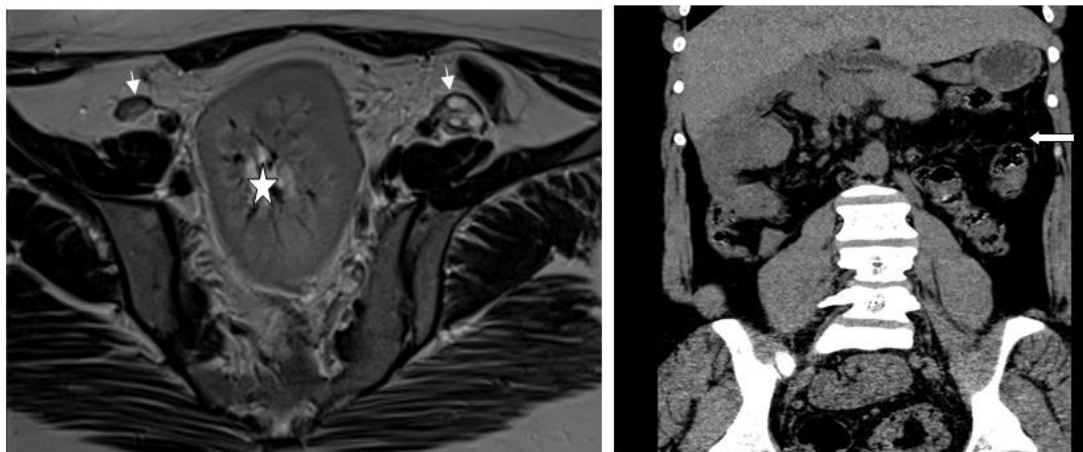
Left pelvic MRI: T2 Axial sequence: normal ovarian morphology and size (arrows), ectopic left pelvic kidney (star).right Abdominal CT coronal section shows empty left renal compartment (arrow)
